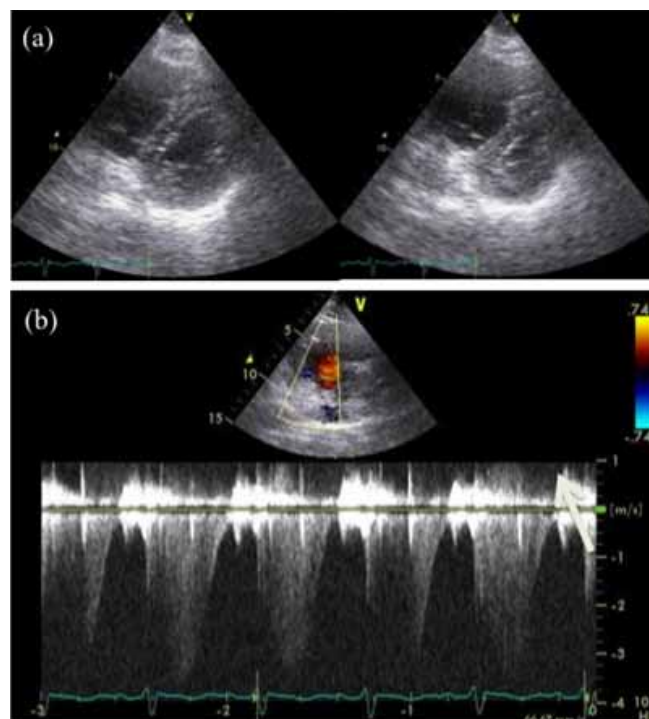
Echocardiography showed right ventricular dilation, flattening of interventricular septum in the left ventricle during diastolic phase (a), and severe pressure gradient estimated with tricuspid regurgitation (b).
